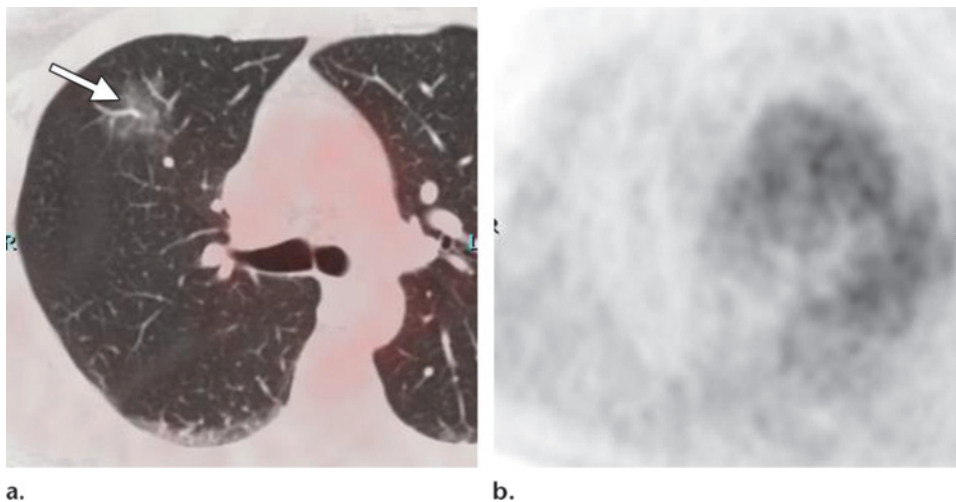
Bronchioloalveolar carcinoma. (a) Axial chest PET/CT image shows a focal area of ground-glass attenuation in the right upper lobe (arrow) without architectural distortion of the lung parenchyma, a finding that was confirmed to be bronchioloalveolar carcinoma at pathologic analysis. (b) Axial FDG PET scan shows only normal physiologic cardiac uptake.
